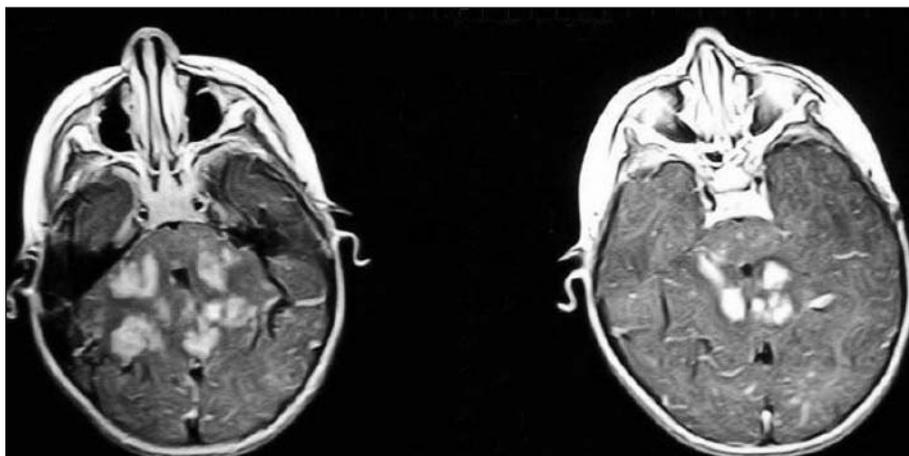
Axial MRI scans showing multifocal abnormal high-signal intensity in the white matter of the cerebellum and brainstem.
